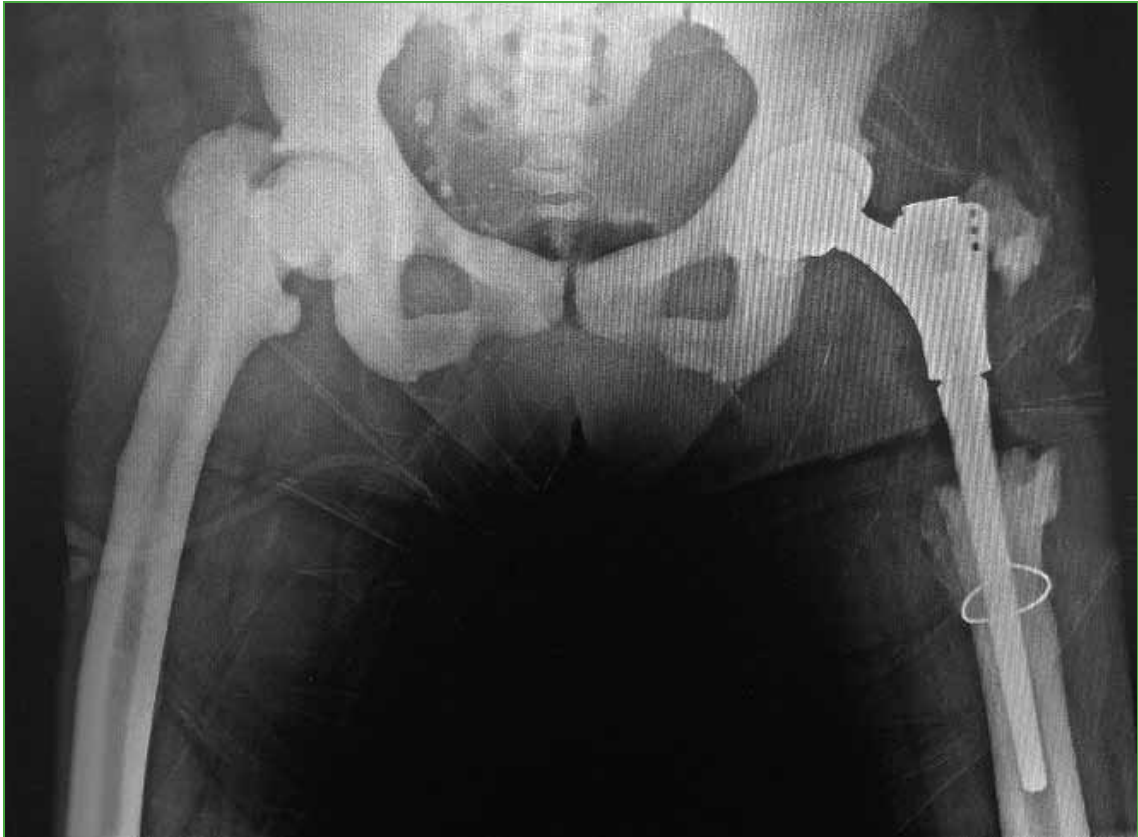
Postoperative control radiograph of total left hip prosthesis plus osteotomy and ostectomy of the proximal femur.
